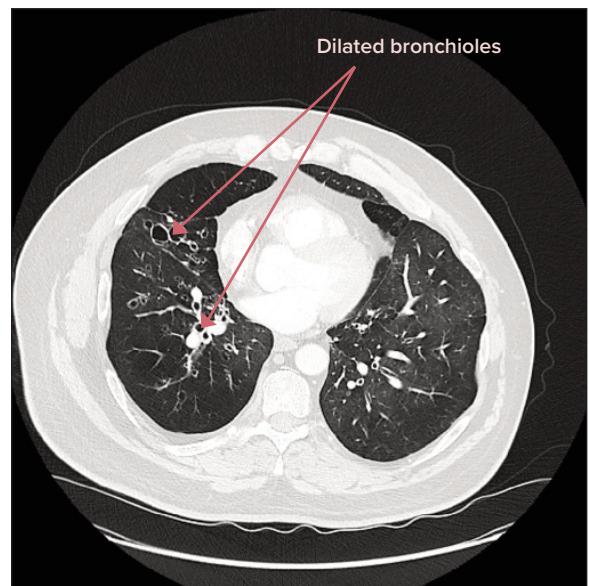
HRCT demonstrating the bronchial dilation diagnostic of bronchiectasis (Quint, Smith, *et al.*, 2019).
